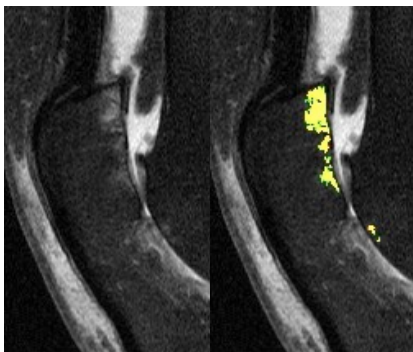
Example of a BML in the patella on MRI (left) and segmented (right). Yellow pixels are where DL and SA overlapped. Red and green pixels are areas of disagreement.
